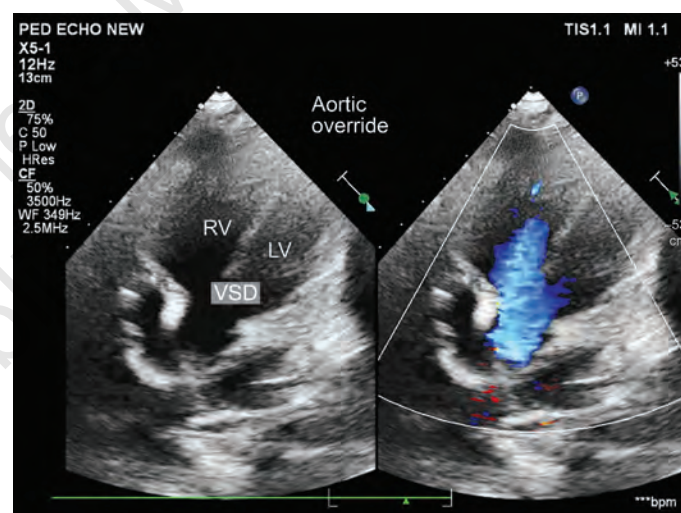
TOF: Apical four-chamber view showing aortic override with a biventricular origin.
